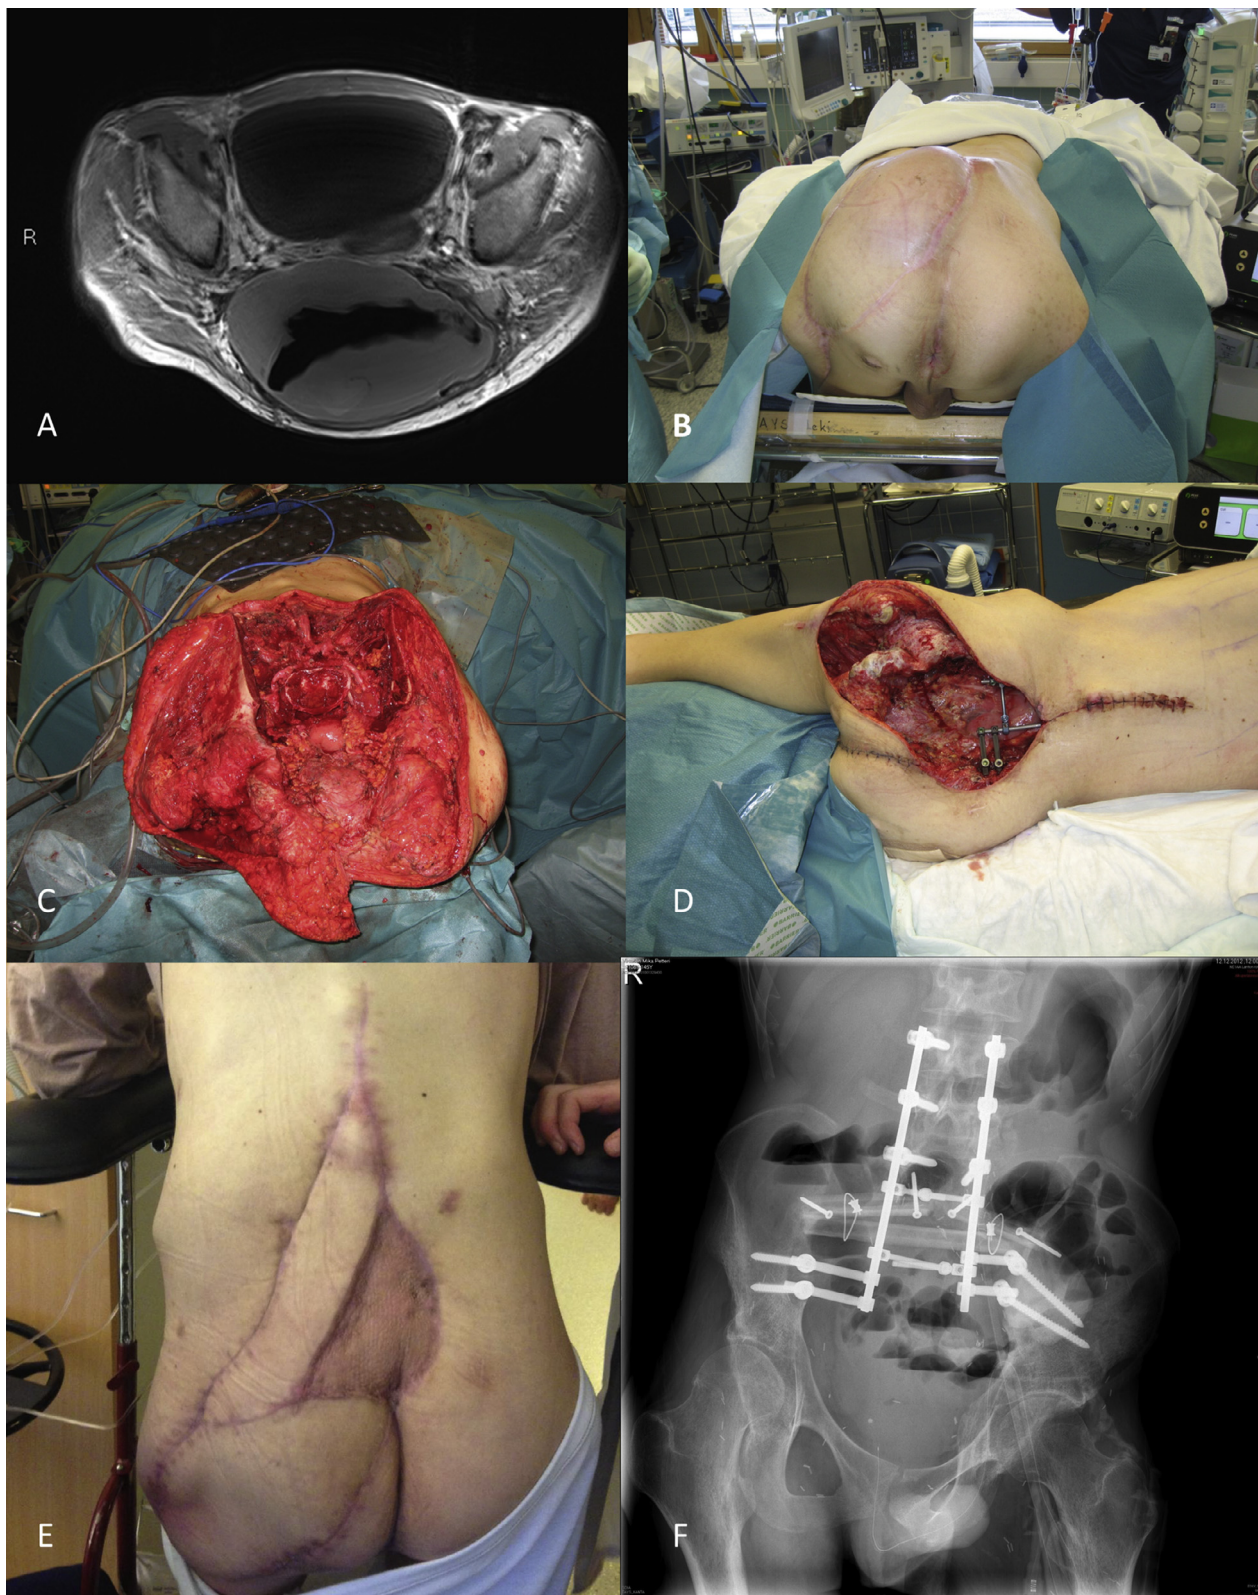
A. MRI of high-grade dedifferentiated sarcoma of the sacrum. B. Status after intra-lesional resection in another hospital before *en bloc* tumour resection. C. After *en bloc* resection of the L5 corpus, sacrum and medial parts of both ilia. Soft tissue resection extended inferior to the trochanter major of the right femur. D. Situation before reconstructive surgery after the removal of negative pressure wound therapy (NPWT). E. Healed LD free flap and pedicled vastus lateralis and ALT flap 1 month after wound healing and immediate rehabilitation. F. Post-operative radiograph.
